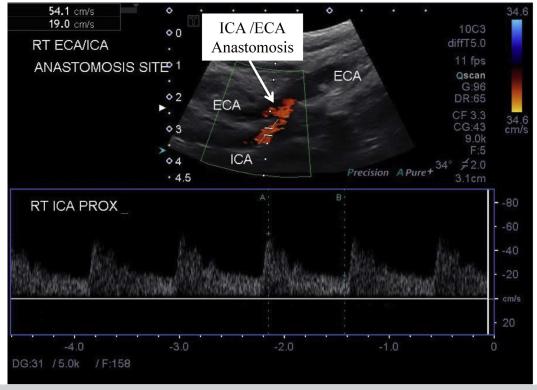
Carotid duplex ultrasound shows the internal carotid artery (*ICA*) bypass to the external carotid artery (*ECA*) with normal ICA velocities.
